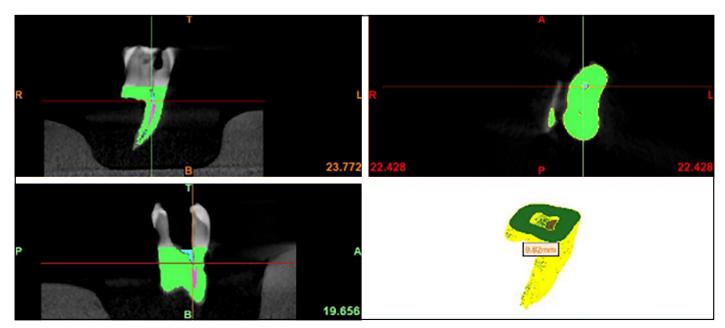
CBCT volumetric analysis of the root before file retrieval using Materialise Mimics software CBCT: Cone-beam computed tomography
